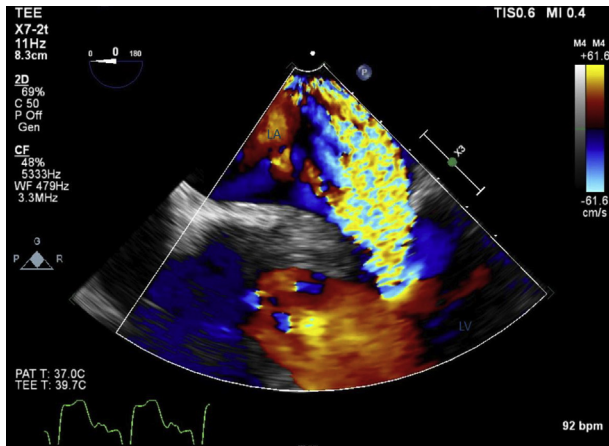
Four-chamber TEE view with color Doppler showing severe mitral regurgitation. LA, Left atrium; LV, left ventricle.
